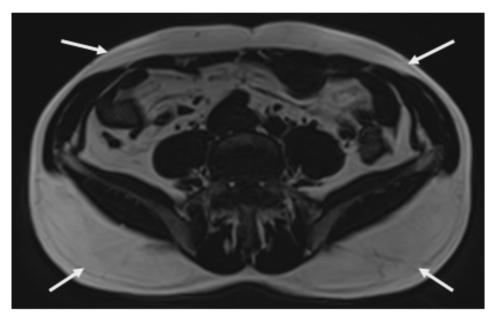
An axial MRI image at the L4-5 anatomical position with the arrows referring to the fascia superficialis that separates dSAT from sSAT.
